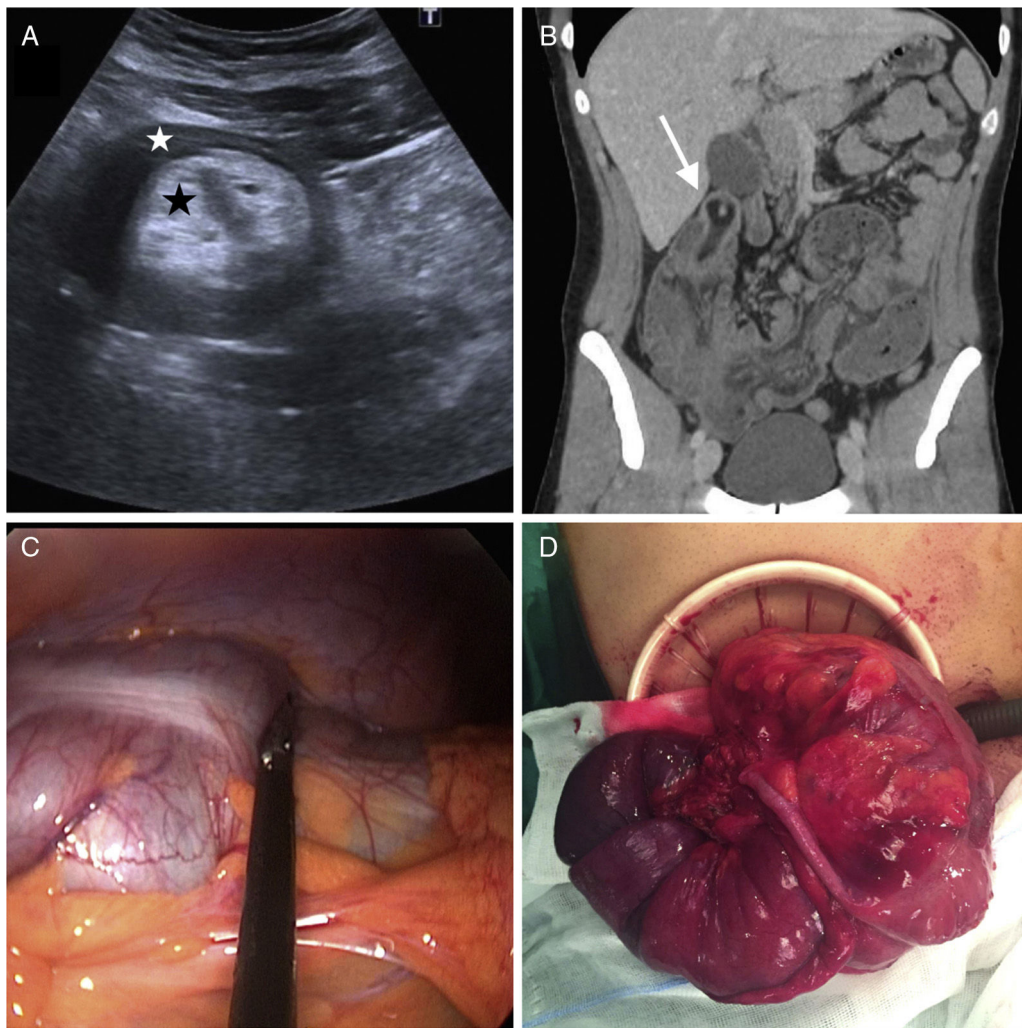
(A) Ultrasound target sign on a transverse section: hypoechogenic (white star) and hyperechogenic (black star) concentric bands. (B) Coronal CT section: hypodense tumour measuring 43 mm at the apex of the intussusception consistent with lipoma of the ileocaecal valve (white arrow). (C) Image of the laparoscopic surgery of the ileocolic intussusception. (D) Extracorporeal image of the ileocolic intussusception.
